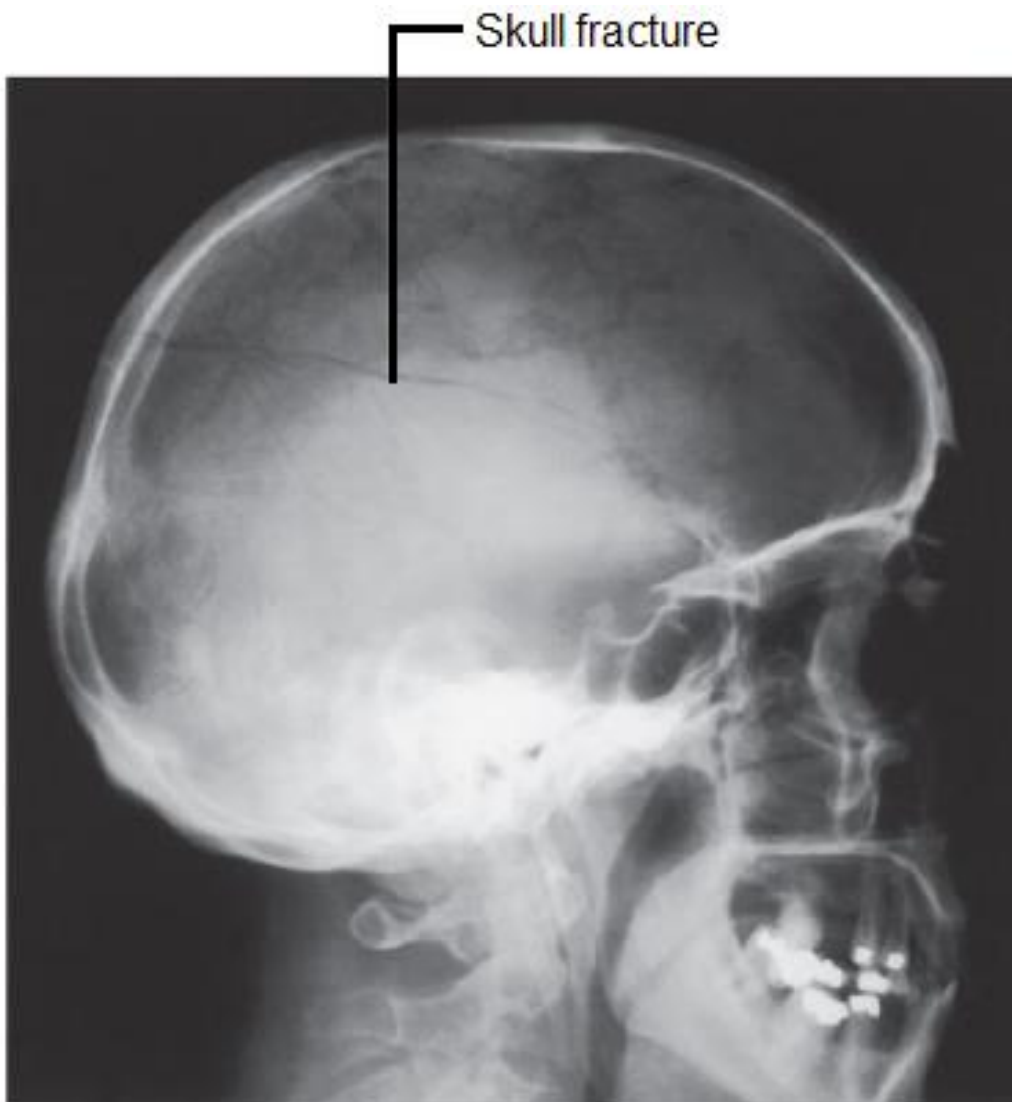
Radiography of the skull.
